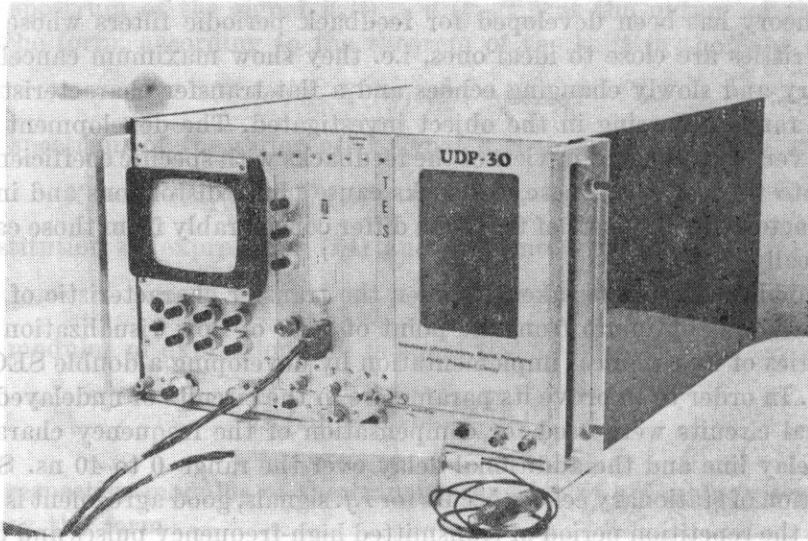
A general view of an ultrasonic pulse Doppler UDP-30-TES flowmeter
